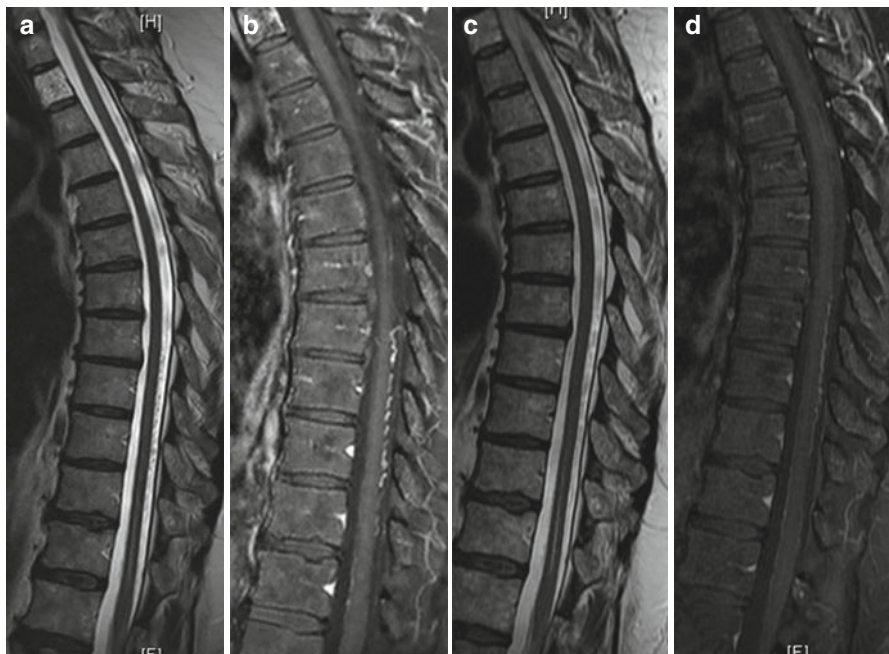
Myelitis mimicking a spinal fistula. A 50-year-old female who presented 6 months earlier with an acute attack of myelopathy with mild progression since. MRI disclosed high signal on T2 images at the center of the cord (a) and some “abnormal vessels” in the thecal sac (*arrow* in b). (c) Follow-up MRI showing improvement in the T2 changes. Now, it looks more like a syrinx. Also seen are CSF flow artifacts behind the cord. (d) Fewer vessels are seen on sagittal T1 post GAD
